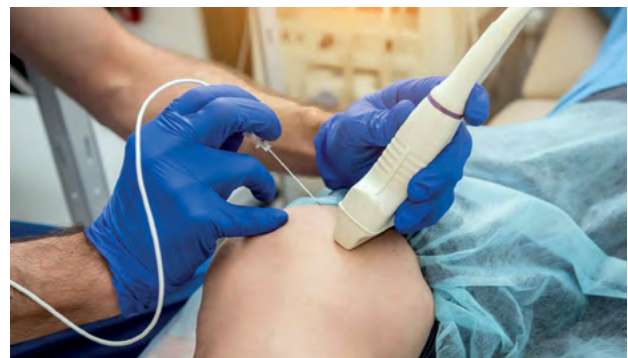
Radiofrequency ablation of the great saphenous vein using duplex ultrasound of the lower extremity veins.
